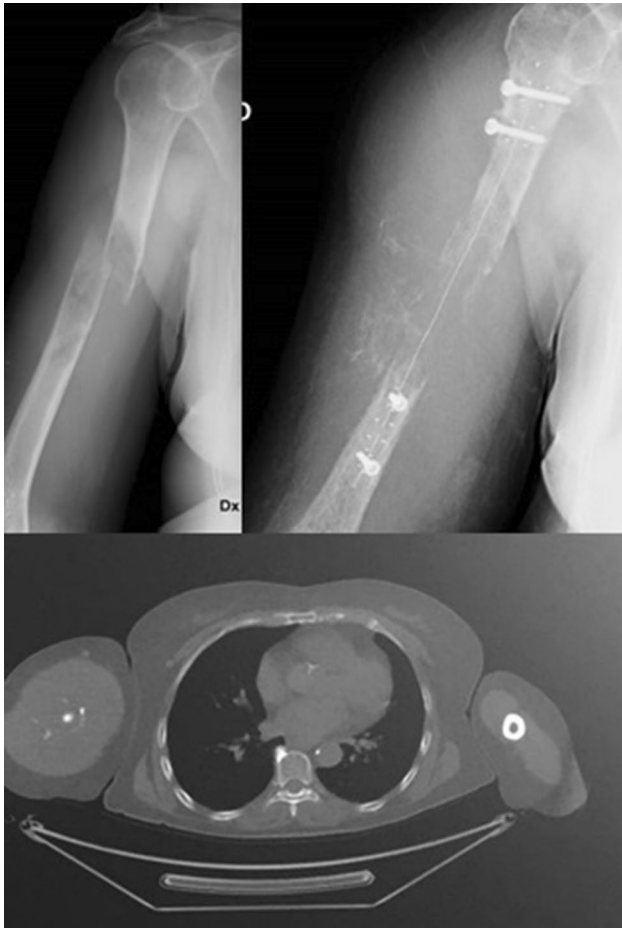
Pathological fracture of the right humerus. Radiolucency of the nails and disease site visibility in the X-rays and in the CT scan images
